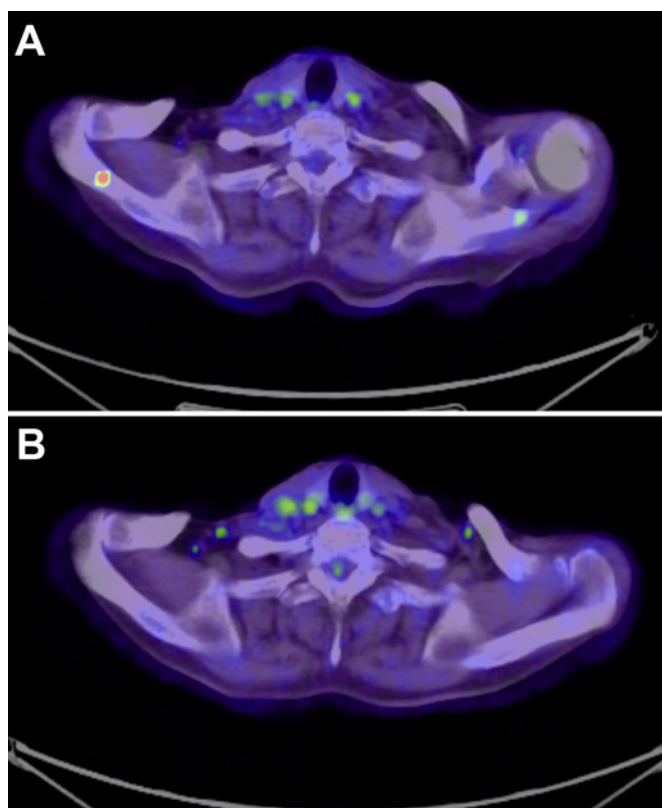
PET-CT image: metastasis at the scapula before (A) and after (B) combination therapy.
